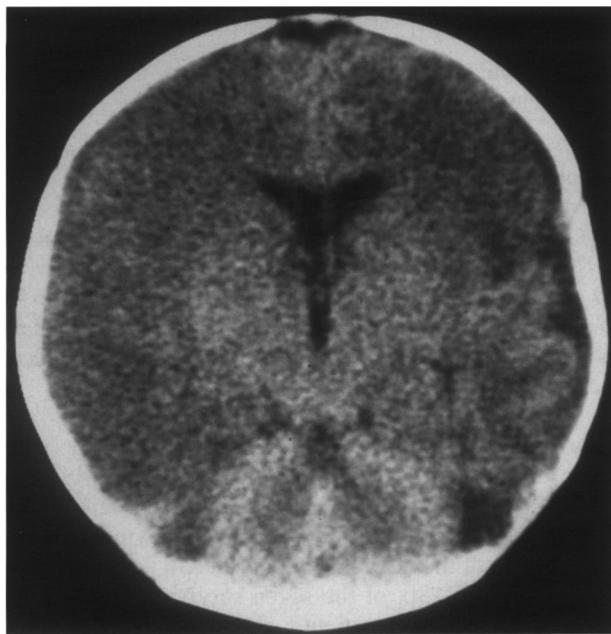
Axial non-enhanced CT through the brain of an abused child above the level of the fourth ventricle demonstrating the Acute Reversal Sign. There is diffusely decreased density of the grey and white matter with loss of grey–white matter differentiation and a relative increase in density of the cerebellum.
